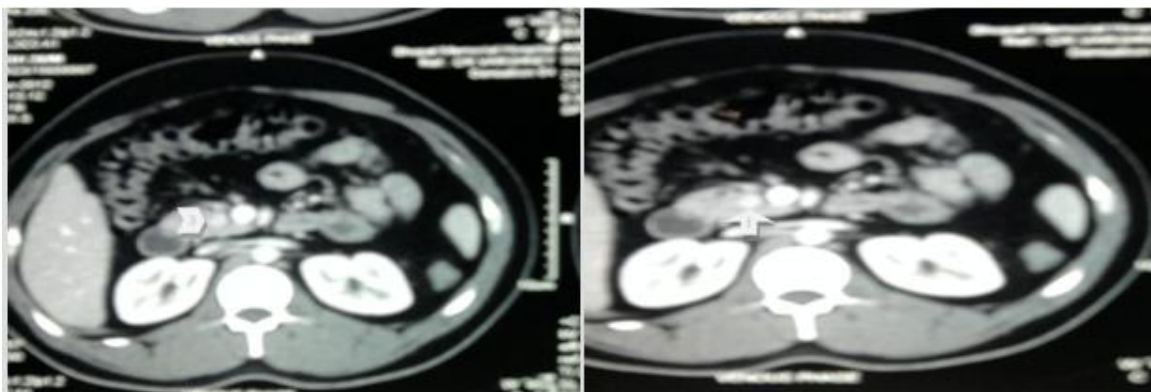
Multislice CT during arterial phase of contrast bolus injection showed a well defined enhancing lesion size of 1.4x1.8 cm (arrowhead) seen in relation to head of pancreas in the uncinata process
